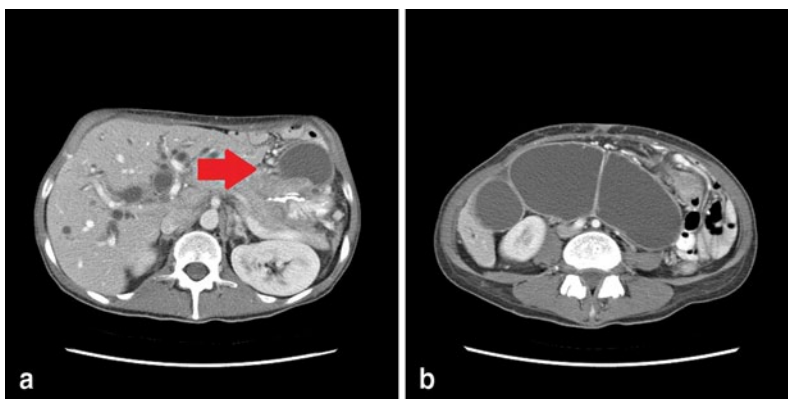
a Computed tomography (CT) image of a patient with afferent limb syndrome due to recurrence of gastric cancer at gastrojejunostomy staple line (*red arrow*).
